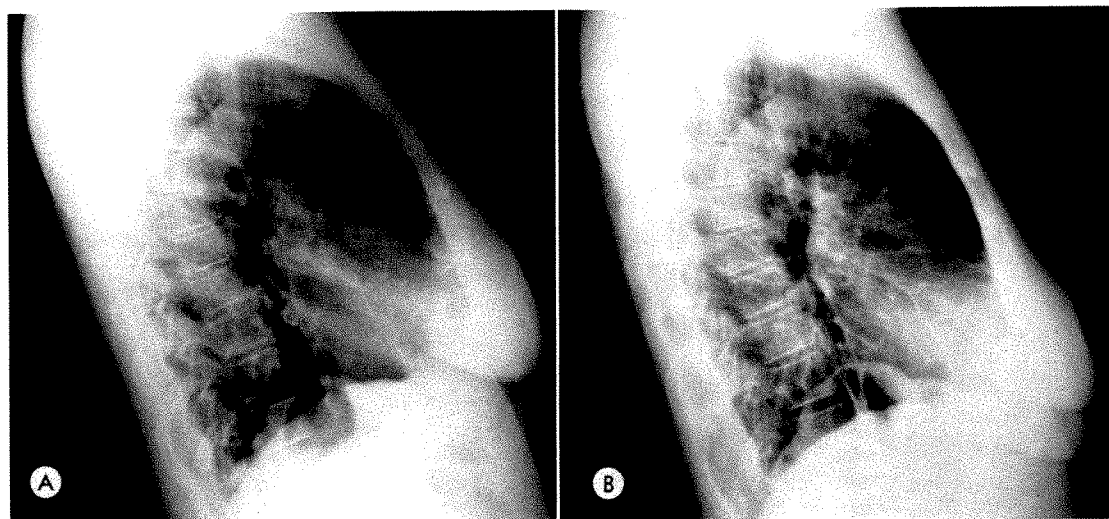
(*A*) Conventional lateral chest roentgenogram. (*B*) Lateral chest roentgenogram made with the triad technique.
